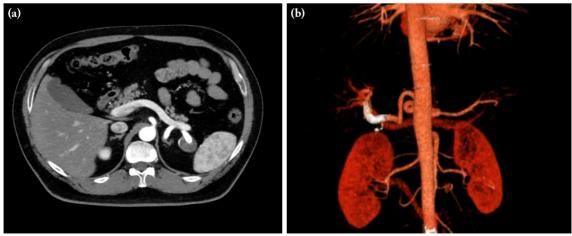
(a) A follow-up CTA performed one month later confirming a complete thrombosis of the aneurysm without signs of an endoleak. (b) The 3D CTA reconstruction shows the positioning of the implanted stent. 3D CTA: Three-dimensional computed tomography angiography.
